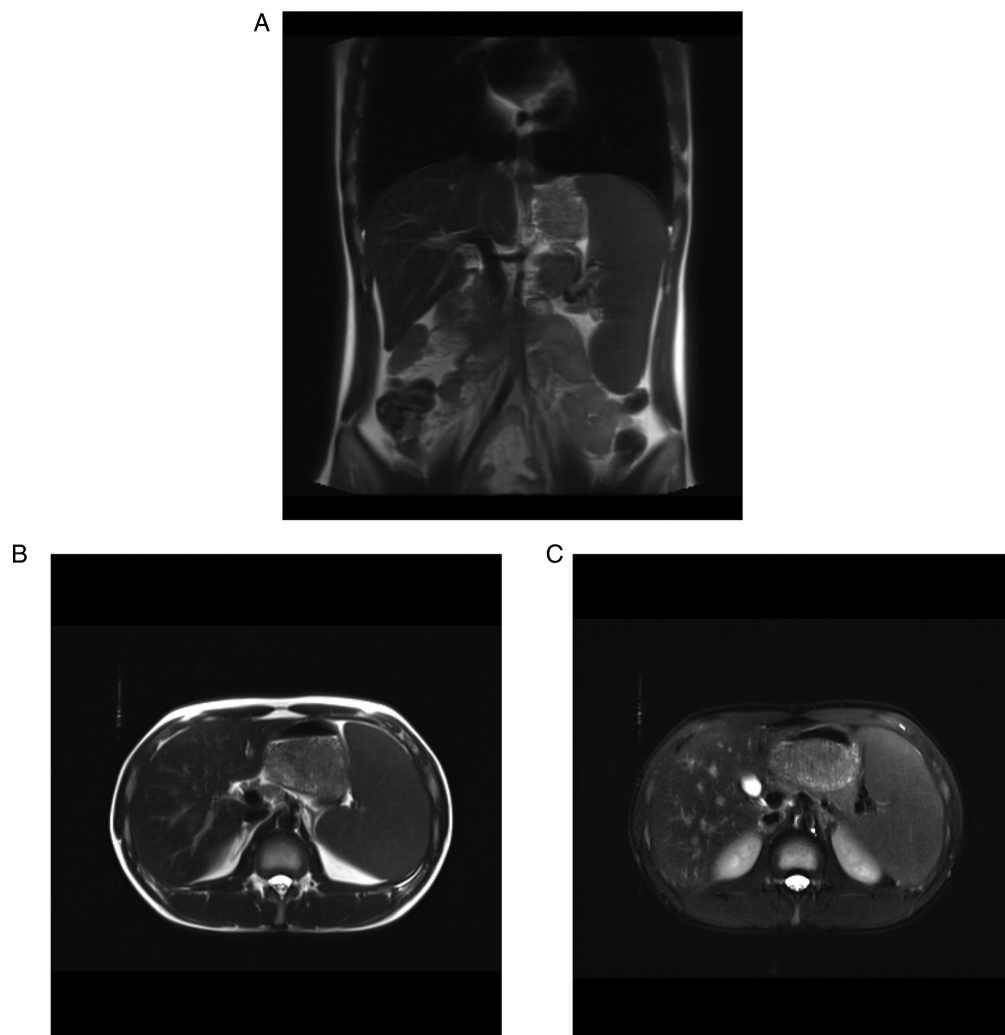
MRI scans of the proband patient. (A) MRI scan of the patient revealing an enlarged spleen. (B) T2 MRI scan and (C) selective partial inversion recovery sequences revealing reduced signal intensity in the spleen, suggesting iron deposition. MRI, magnetic resonance imaging.
